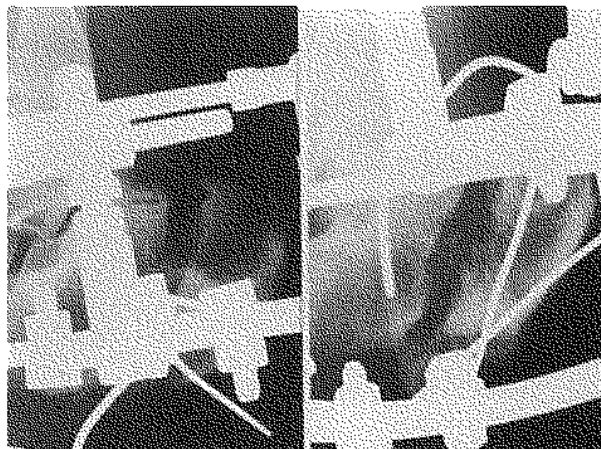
Osteotomy of the calcaneal tuberosity and Ilizarov fixation (radiograph at one centimeter of distraction).
